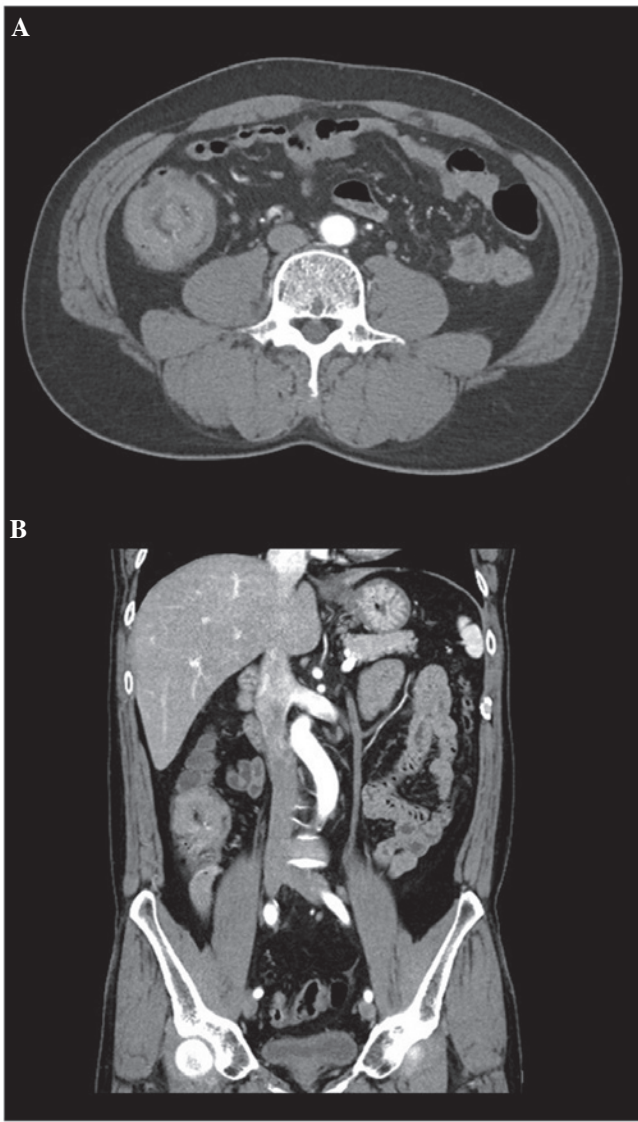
Contrast-enhanced abdominal computed tomography (CT) scan of the abdomen demonstrate (A) the finding of a target like an ileocolic intussusception and (B) round mass lesion with focal enhancement.
